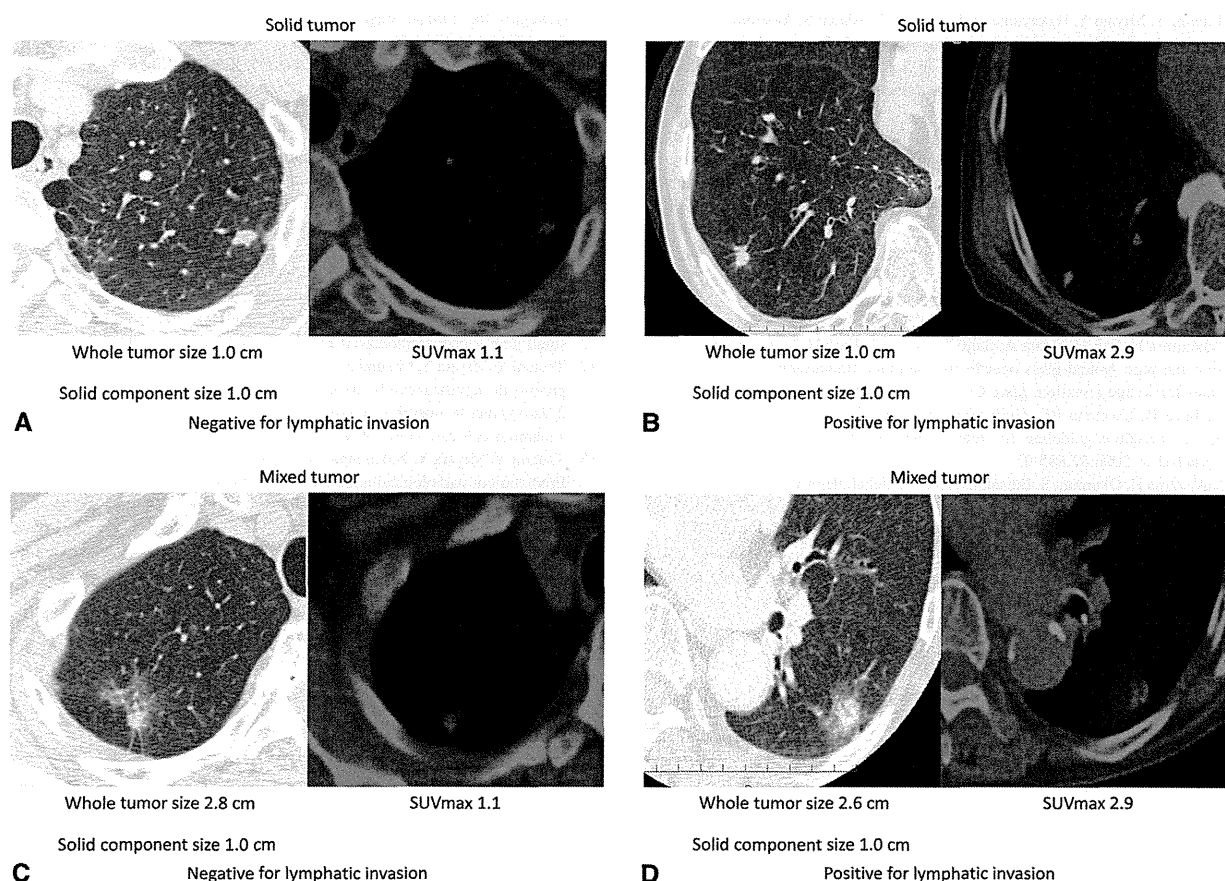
Examples of solid and mixed tumors on HRCT. A, Whole tumor size = solid component size: 1.0 cm, SUVmax: 1.1. This solid tumor was negative for lymphatic invasion. B, Whole tumor size = solid component size: 1.0 cm, SUVmax: 2.9. This solid tumor was positive for lymphatic invasion. C, Whole tumor size: 2.8 cm, solid component size: 1.0 cm, SUVmax: 1.1. This mixed tumor was negative for lymphatic invasion. D, Whole tumor size: 2.6 cm, solid component size: 1.0 cm, SUVmax: 2.9. This mixed tumor was positive for lymphatic invasion. *SUVmax*, Maximum standardized uptake value.
